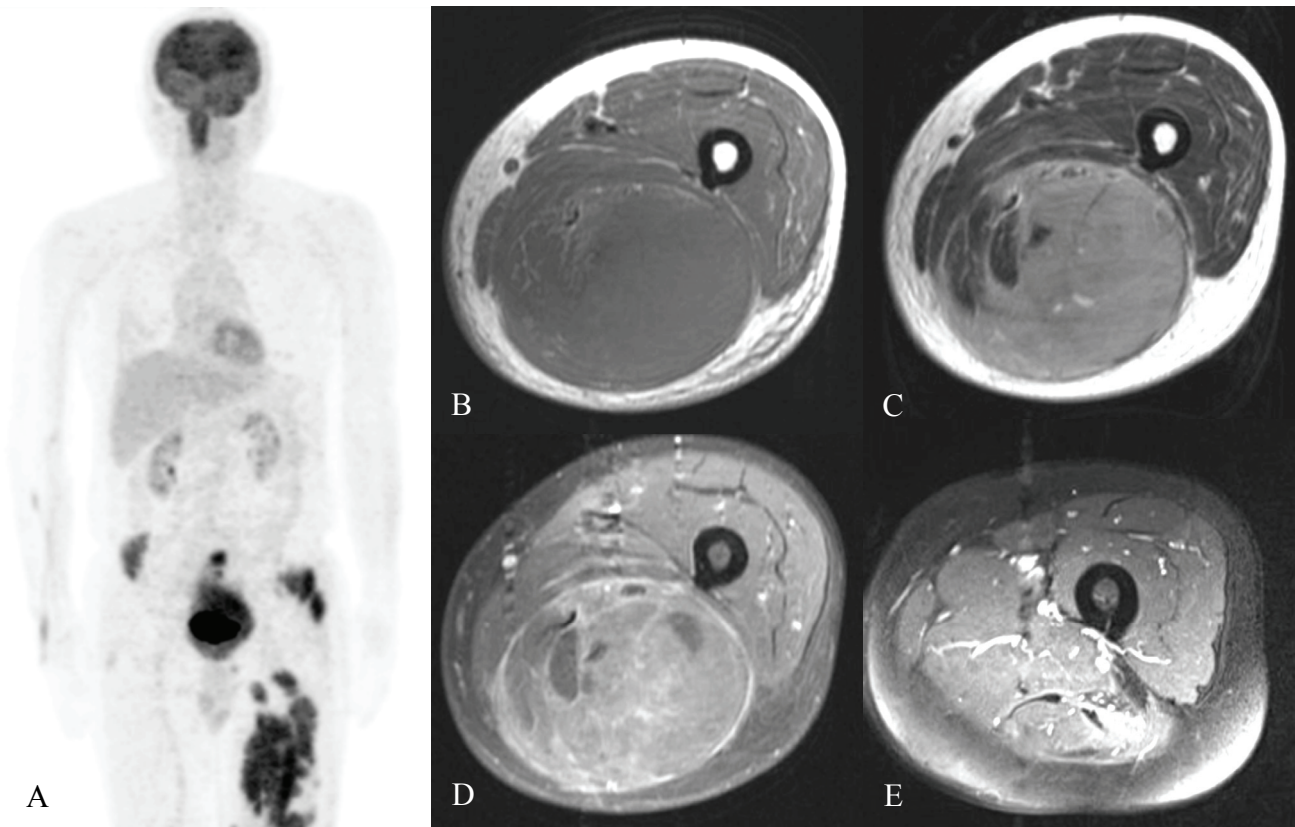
Images of Case 2. (A) FDG-PET in maximal intensity projection mode, showing nodular intense hypermetabolic areas involving the left thigh, pelvic cavity, and right nuchal muscles. (B) T1-weighted axial MR image at the level of mid thigh, showing isointense left hamstring muscular enlargement. (C) T2-weight image at the same level. The involved muscles showed hyperintensity. (D) Gd-enhanced T1-weighted image with fat-saturation, showing mild homogeneous contrast enhancement. (E) Gd-enhanced T1-weighted image with fat-saturation after six courses of R-CHOP chemotherapy, showing resolved intramuscular mass with faint traces of contrast enhancement
